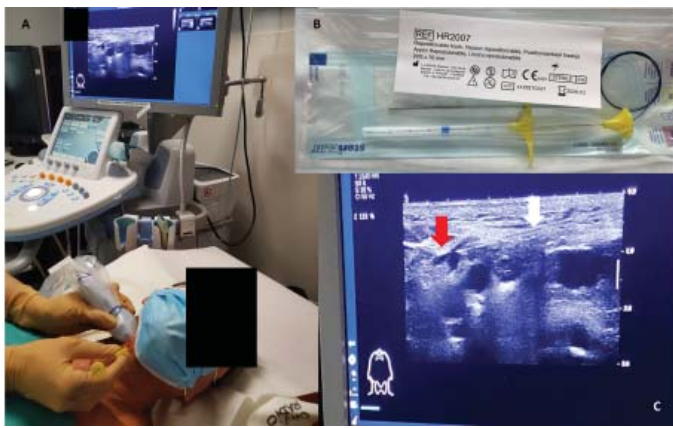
Ultrasound-guided harpoon positioning in patient No. 5. A: position of the patient. B: Fil d'Ariane™, Laurene Medical, Le Pradet, France. C: Zoom on the ultrasonography screen (red arrow = target/harpoon, white arrow = path of the needle)
